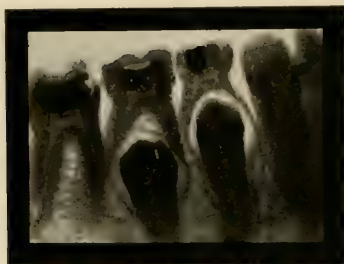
This picture shows that the temporary first molar may be extracted. The temporary second molar should not be extracted for a year or so, when the second bicuspid will be just ready to take its place. (Radiograph by Lewis, of Chicago.)
